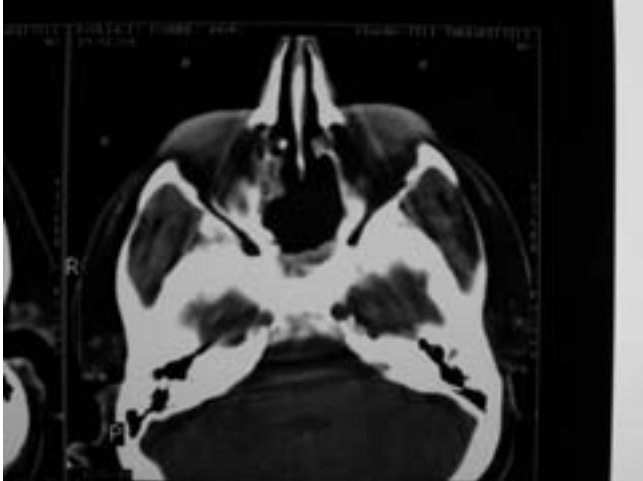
Axial CT view of patient, case No 2, 12 months postoperatively. No signs of recurrence were found.
